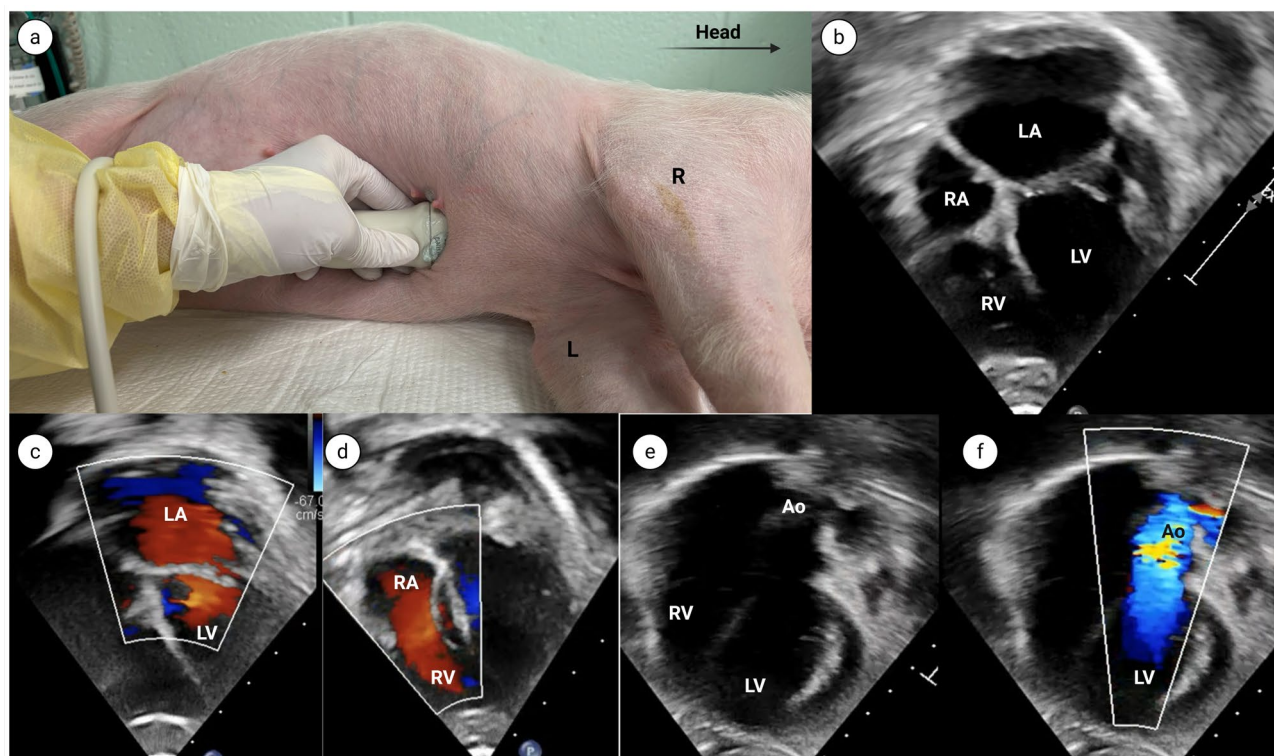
Apical 4 chamber view.
